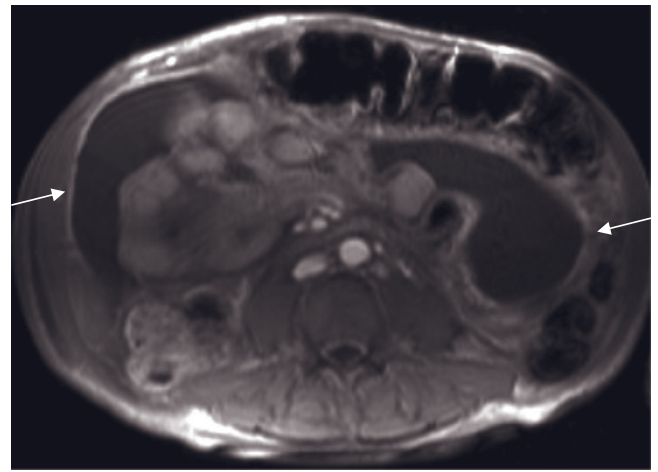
Peritonitis. Transverse T2-weighted SS-ETSE (a) and transverse (b) and sagittal (c) interstitial-phase gadolinium-enhanced SGE images. There is a large volume of ascites seen throughout the abdomen. The ascites in the pelvis appears complex, containing septations (arrows, a), best shown on the single-shot T2-weighted sequence (a) and increased peritoneal enhancement, shown on the gadolinium-enhanced fat-suppressed images (b, c), consistent with peritonitis. Continuity of the large volume of ascites extends through a low ventral hernia (arrow, c) into the anterior upper thigh. Transverse T2-weighted SS-ETSE (d) and gadolinium-enhanced fat-suppressed T1-weighted SGE (e) images of a pregnant patient with peritonitis secondary to Crohn disease. Inflammatory debris in the peritoneal cavity is best visualized on T2-weighted SS-ETSE image (arrowheads, d); increased peritoneal enhancement is demonstrated on gadolinium-enhanced fat-suppressed SGE images (arrowheads, e). Thickened bowel wall is also appreciated (arrows, d, e). T2-weighted single-shot
